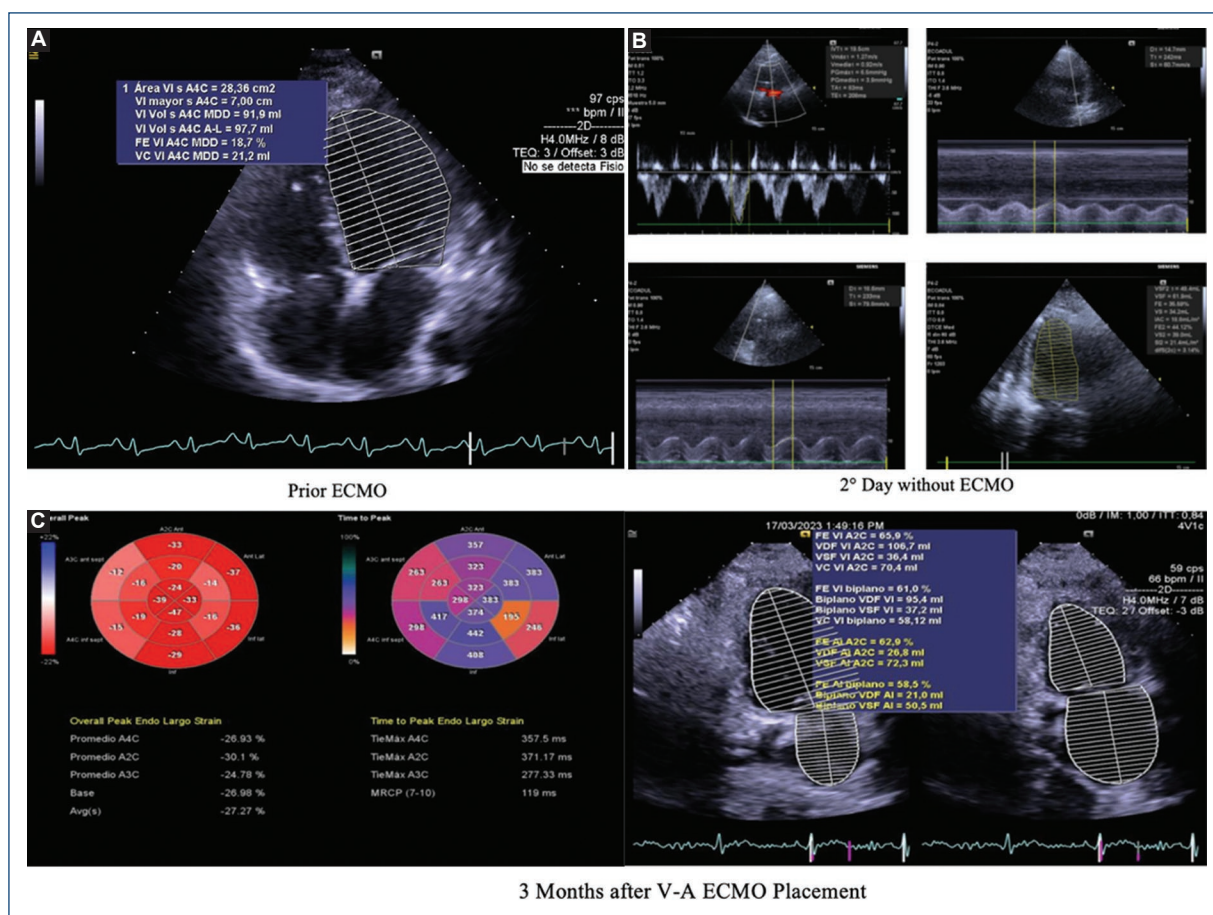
A transthoracic echocardiogram was performed before and after V-A ECMO. A: day before ECMO placement. Transthoracic echocardiogram hours before starting VA-ECMO therapy shows LVEF by Simpson's method at 22%. B: 2° day without ECMO. Transthoracic echocardiogram 2 days after retiring VA-ECMO shows LVEF improved at 42% by Simpson's method. C: 3 months after V-A ECMO placement with LVEF. V-A ECMO: venoarterial extracorporeal membrane oxygenation; LVEF: left ventricular ejection fraction.
